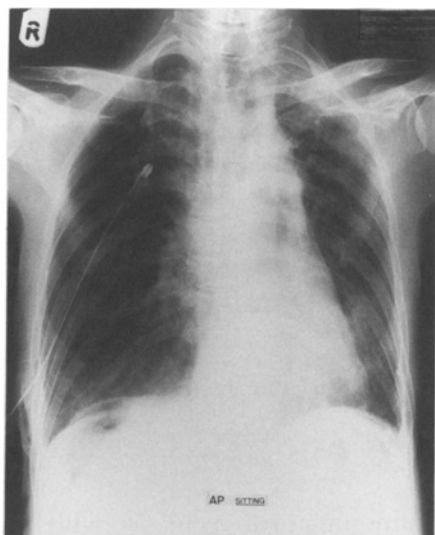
Chest X-ray immediately after attempted right internal jugular vein cannulation.
